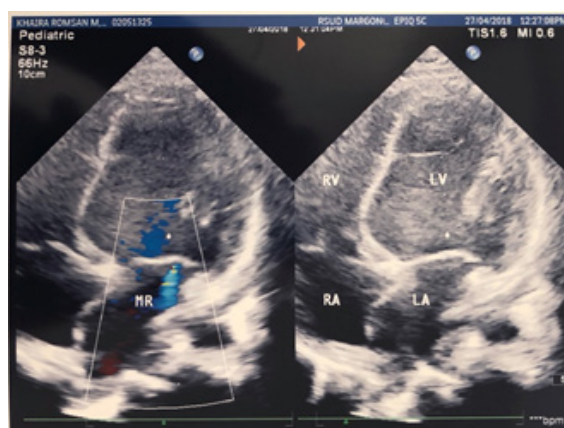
Echocardiogram of the Patient
